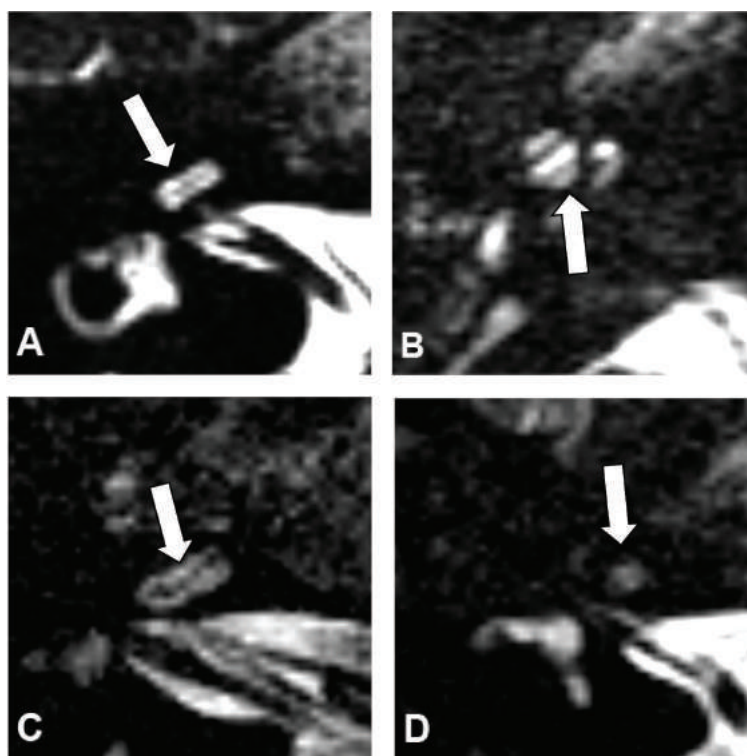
Grading of cochlear patency. Axial 3D heavily T2-weighted MRI images showing different grades of intensity or fluid distribution within the cochlea (arrows). A, Grade 0: hyperintensity or no loss of fluid (Patient 12), B, Grade 1: partial and irregular loss of fluid (Patient 2), C, Grade 1: moderate hypointensity (Patient 9), D, Grade 2: severe hypointensity or severe loss of fluid (>50%) (Patient 13).
